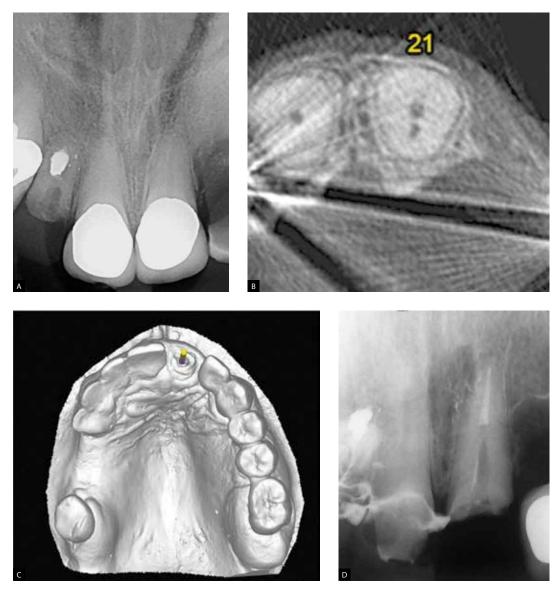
A) Initial radiograph. B) Cone beam computadorized tomography. C) 3D model. D) Final radiography.
